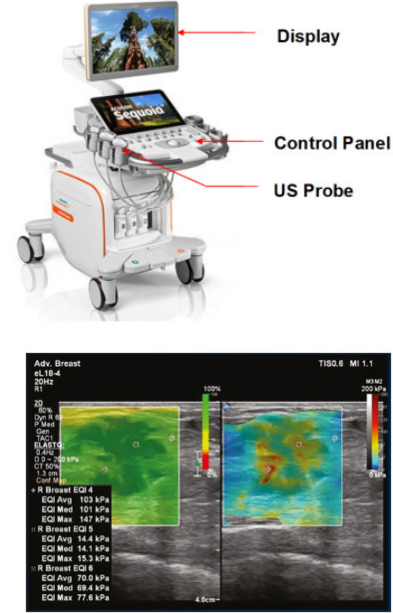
The ultrasonic elastography system and its image sample. (a) The conventional ultrasonic elastography modality [83], (b) The breast elastogram [84]
